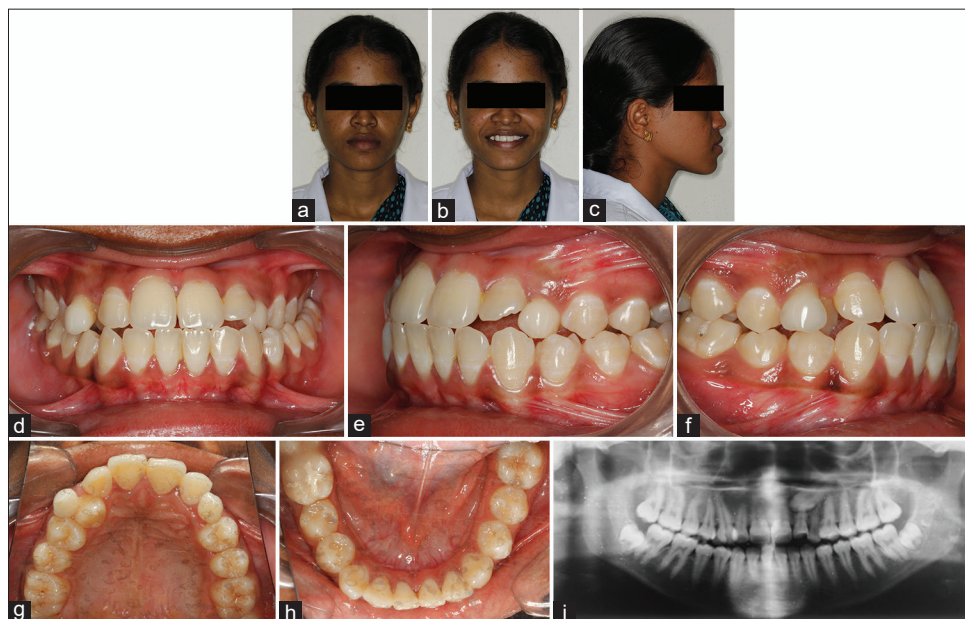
Pretreatment photos. (a) Extraoral frontal. (b) Extraoral smile. (c) Extraoral profile. (d) Intraoral frontal. (e) Left lateral. (f) Right lateral. (g) Upper occlusal. (h) Lower occlusal. (i) Pretreatment orthopantomogram
